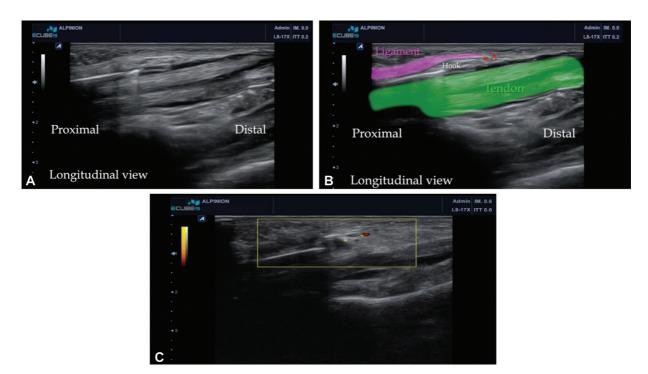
(A, B, C) Insert the Acufex 3.0-mm hook knife with a retrograde blade. Ultrasound view on the longitudinal plane. We must advance and stop before the arterial palmar arch.
